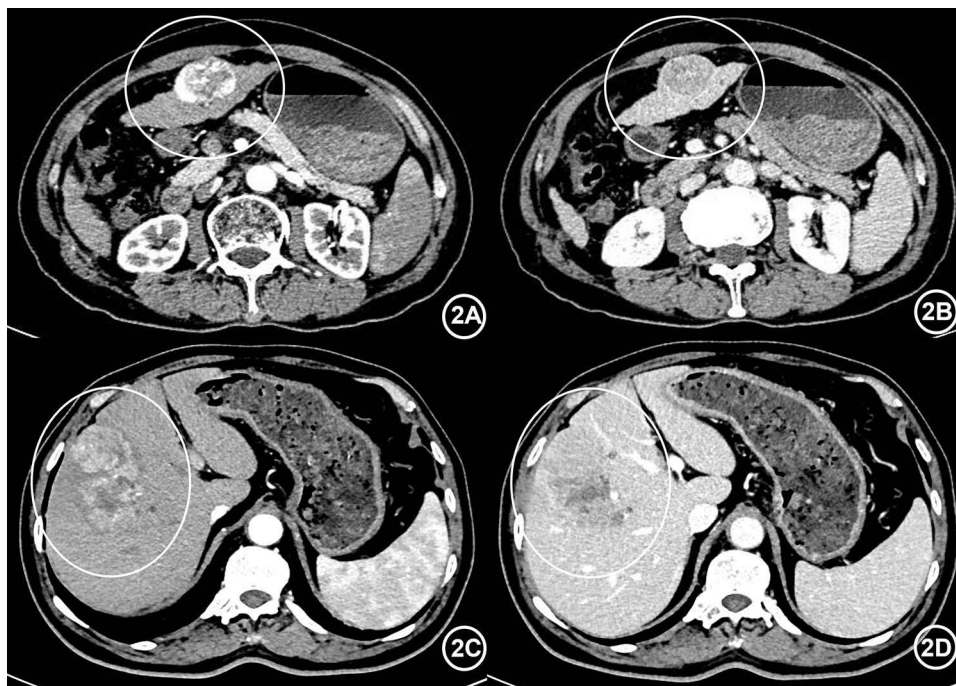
MVI-related imaging. (2A and 2B) A 82-year-old man with HCC, MVI (-). AP (2A) and PVP (2B) images show smooth tumor margin, tumor capsule, intratumoral artery, and typical enhancement pattern. The maximum tumor length is 41mm. The CT value in AP and PVP are 157Hu and 104Hu respectively. (2C and 2D): A 65-year-old man with HCC, MVI (+). AP (2C) and PVP (2D) images show irregular tumor margin, intratumoral artery, cystic, degeneration or necrosis, and typical enhancement pattern. The maximum tumor length is 76mm. The CT value in AP and PVP are 97Hu and 104Hu respectively.
